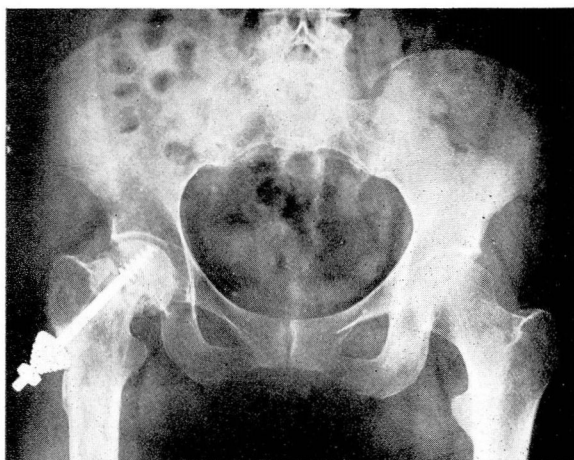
Roentgenogram showing degree of leg shortening before operation in case shown in fig. 12.
